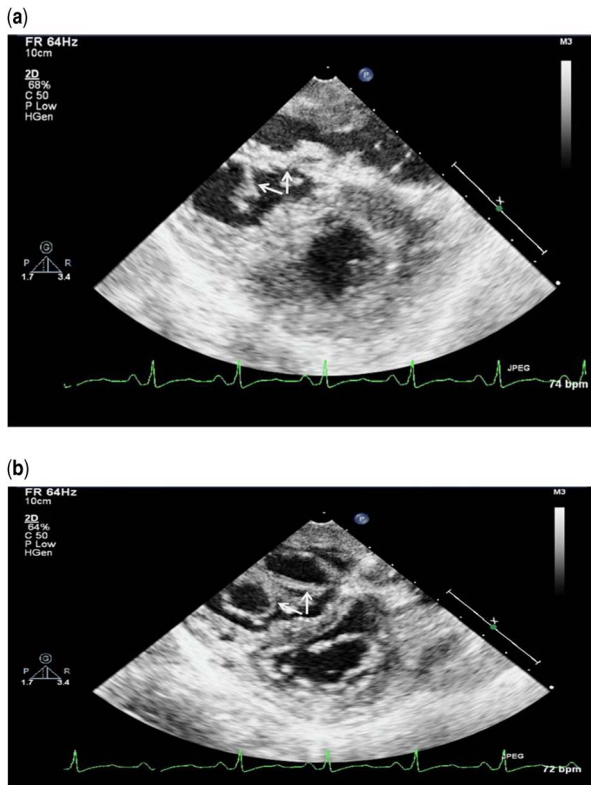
Epicardial echocardiograms show a double-orifice tricuspid valve in systole (a, valve closed) and diastole (b, valve open) in a 35-year-old patient who underwent resection of subvalvar right ventricular outflow tract obstruction. The double-orifice tricuspid valve forced a ventricular rather than an atrial approach for adequate resection because of the small orifices of the tricuspid valve.⁵
